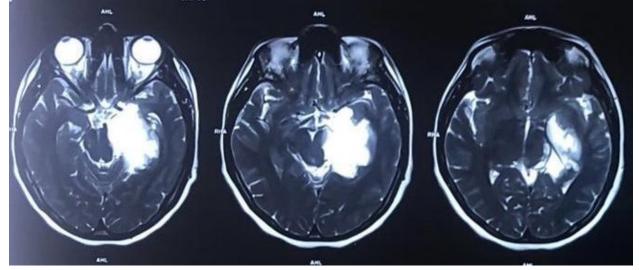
pre op image of MRI T2W shows illdefined nonenhancing hyperintense extraaxial lesion in left medial temporal region
